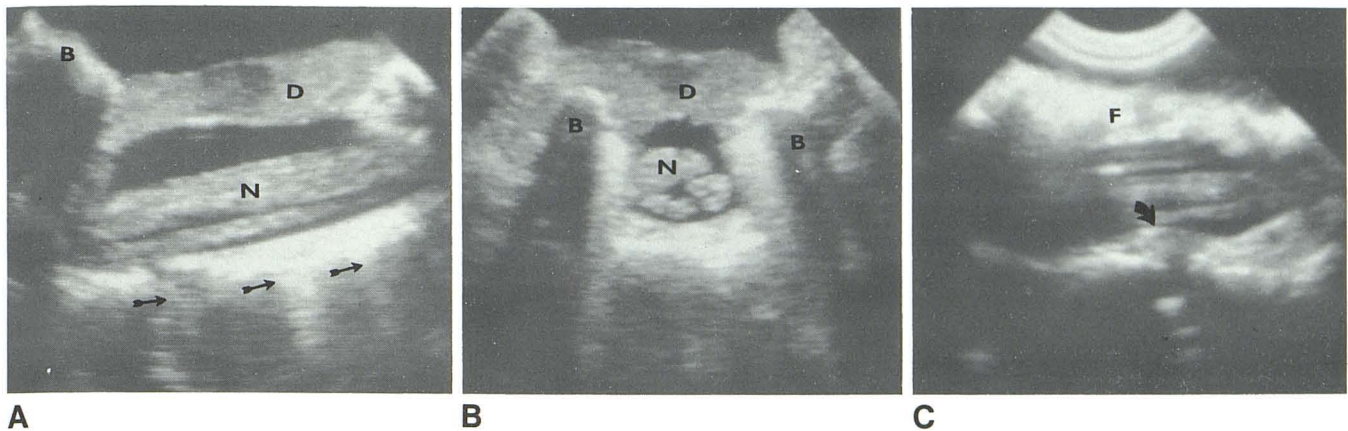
Case 4. A, Longitudinal intraoperative sonogram after lumbar laminectomy. Hypertrophic bone (B) from prior laminectomy, layer of debris (D) that has fallen out of solution from saline suspension onto dural sheath, nerve roots (N) bathed in CSF, and normal disk spaces (arrows). B, Transverse intraoperative sonogram after lumbar laminectomy. Bony facets (B), dural
